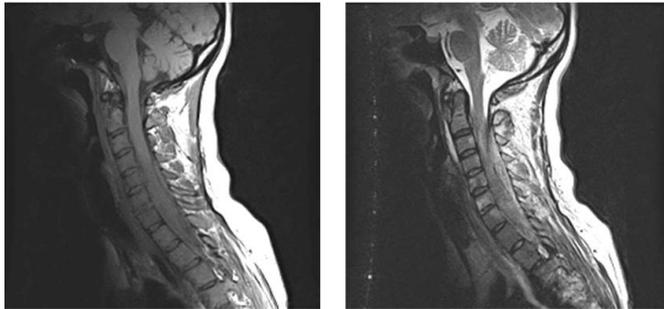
MRI cervical spine minimally contrast enhancing, left sided anterolateral extra dural lesion extending from C2 – D1 level with maximum involvement around C4- C6 level with displacement and compression of cord involving the bone
